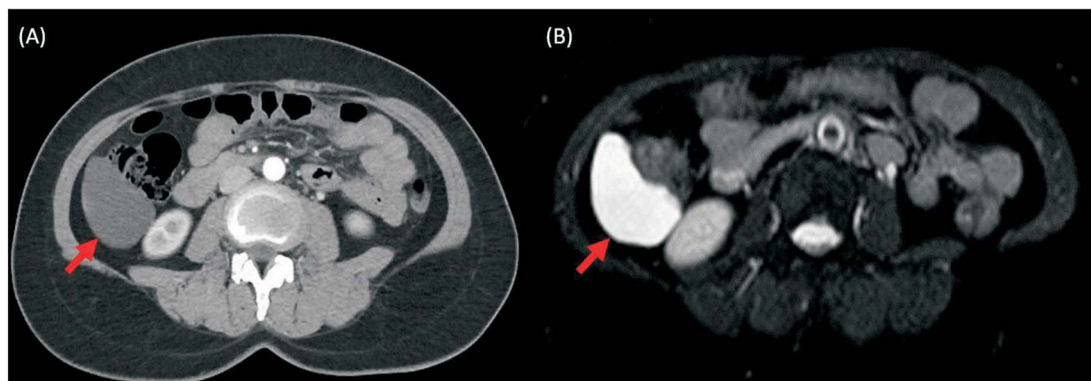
The image studies. (A) Axial view of CT showed a poor enhanced mass in the right subhepatic region (red arrow). (B) T2 fat suppression MRI revealed lobular-contour cystic lesion (red arrow).
